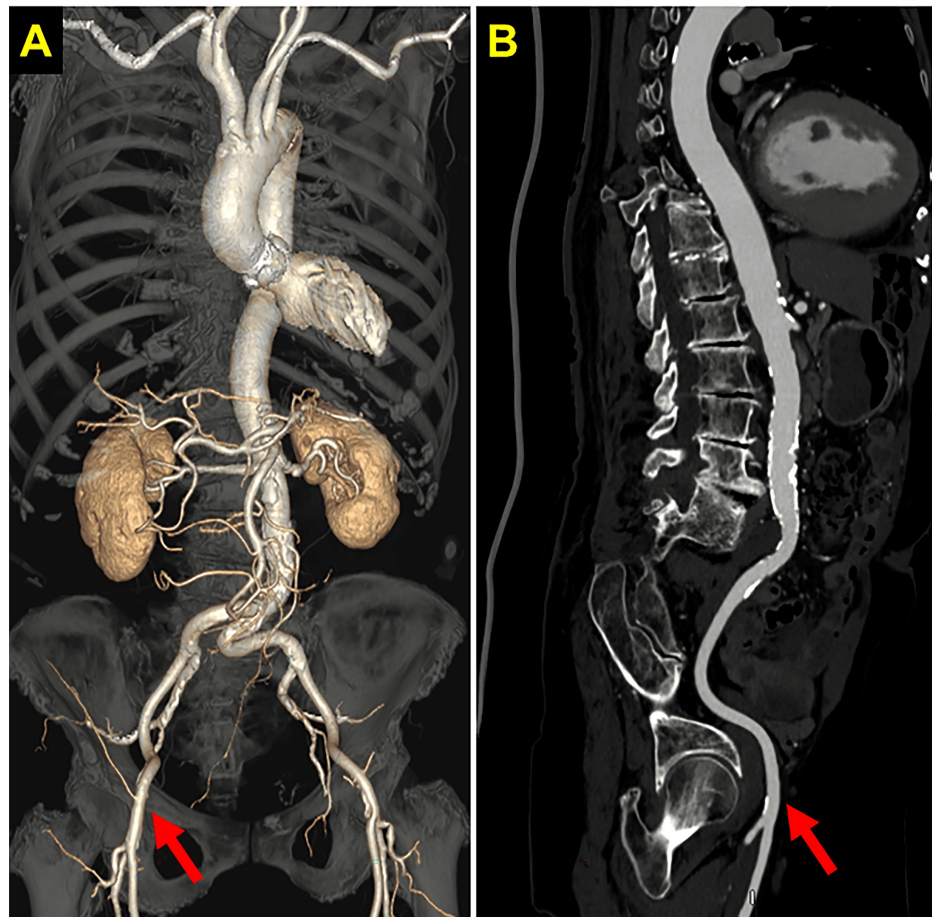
Findings of pre-procedural enhanced computed tomography
